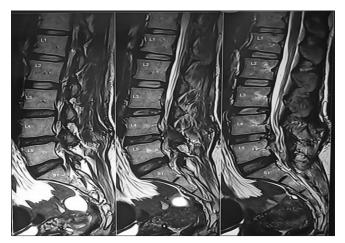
Postoperative T2-weighted sagittal magnetic resonance imaging demonstrating the decompression.
